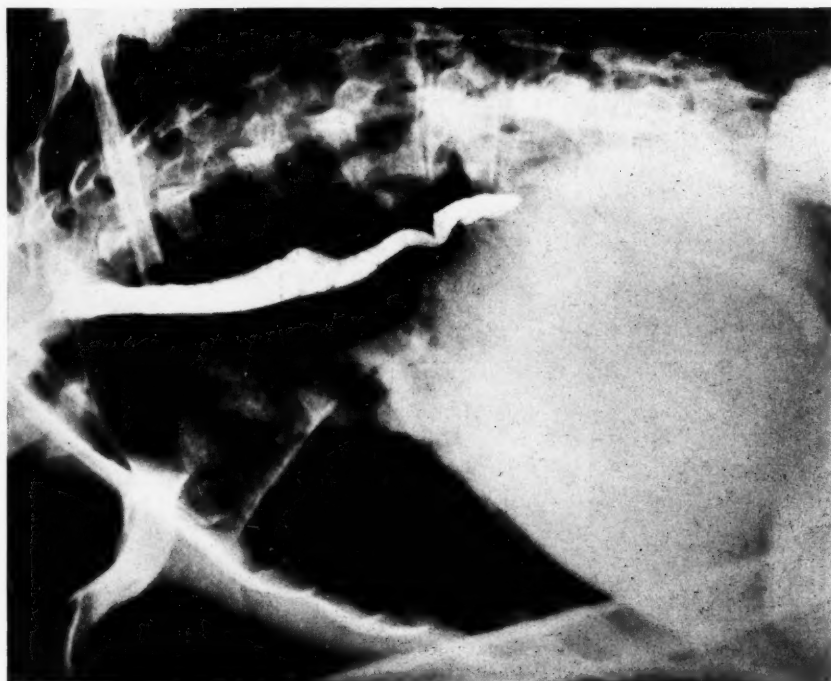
Case 1. Left anterior oblique radiograph showing indentation of the barium-filled oesophagus by the left main bronchus. This bronchus is displaced upwards by the massive left auricle
